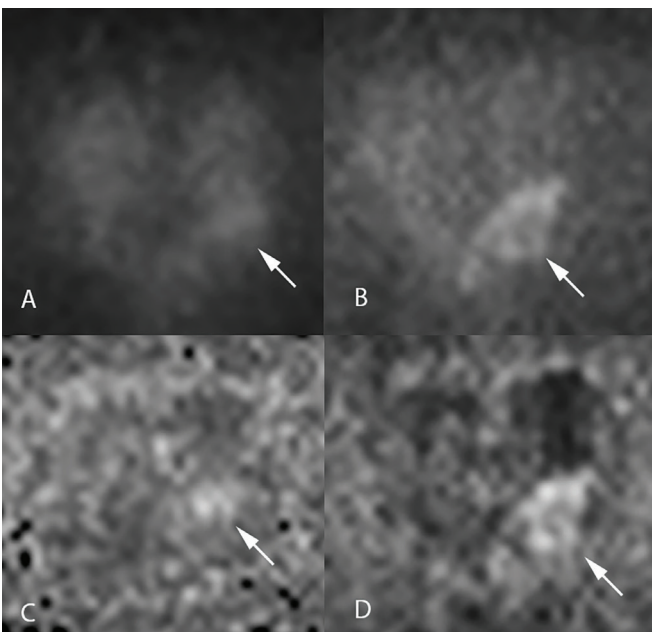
The lesion is not clearly demarcated on b800 DWI (A). In the computed b1400 DWI (C) and computed b2000 DWI (D), the tumour can be seen more clearly (arrow), and it is promising as a technology that can be used in prostate MRI imaging for centres with insufficient MR technology
